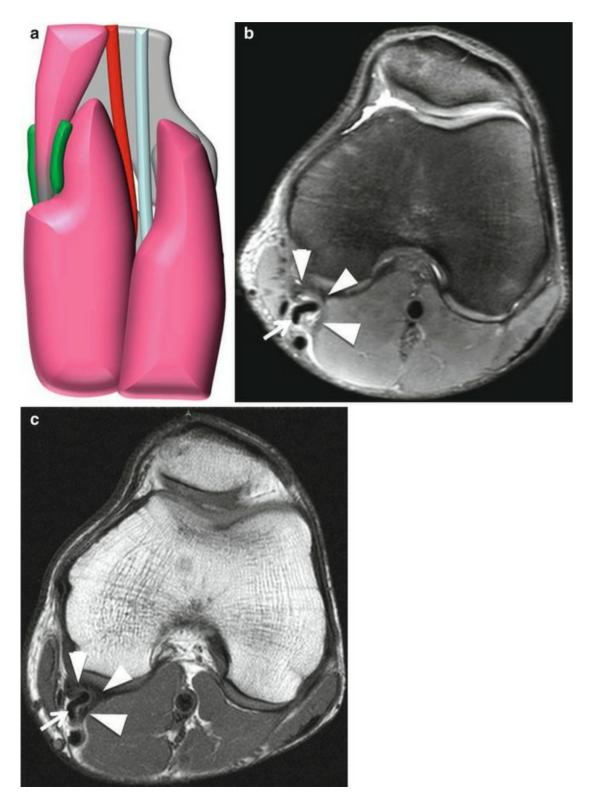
A 32-year-old male patient with postero-medial pain of the knee when running. Posterior view of the right knee (a) shows the impingement of the proximal gastrocnemius and distal semi-membranosus tendons. Axial proton density- (b) and T1-weighted (c) MRI of the right knee demonstrate the proximal fibers of the gastrocnemius muscle (arrowheads) embedding themselves into the semi-membranosus tendon (arrow). Mild edema surrounding the semi-membranosus tendon is visible. Ultrasound-guided block-test with steroids resolved symptoms for a few weeks, thus confirming the presence of an extra articular impingement
